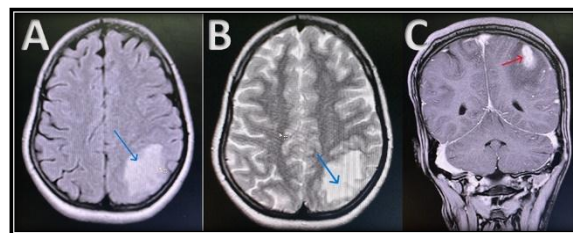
(case 9) FLAIR (A), T2 (B) AND CISS sequence (c) showing conglomerated NCC in colloid-vesicular stage with perilesional oedema.
